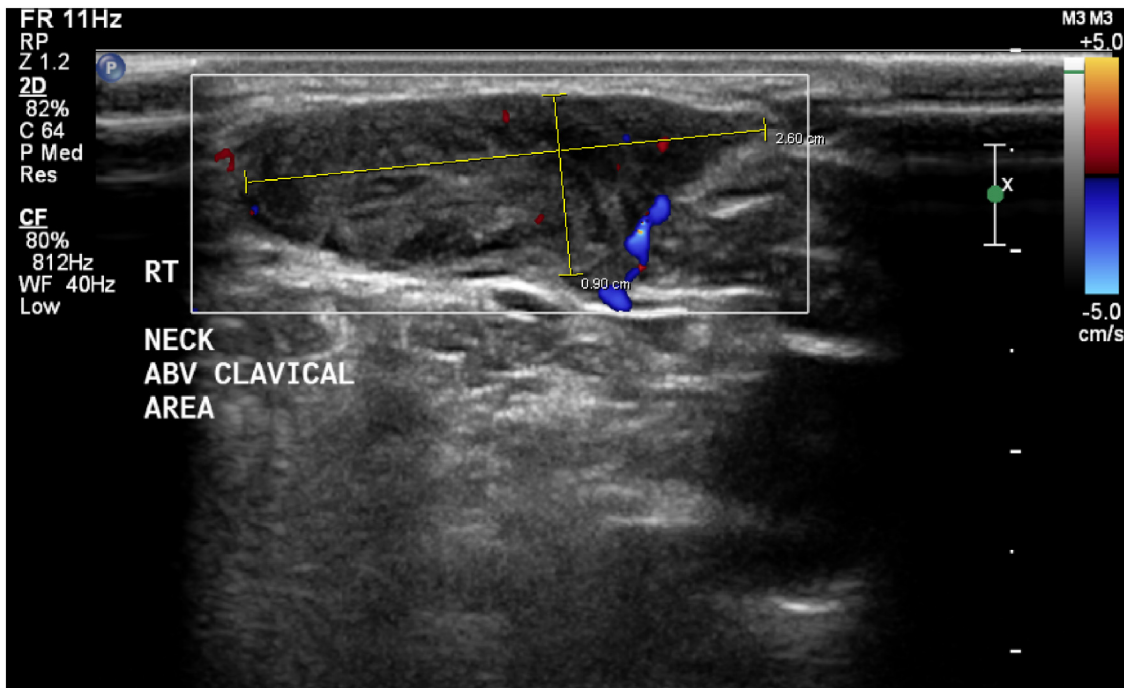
Pre-operative ultrasound imaging showing "cystic mass of the right neck".
